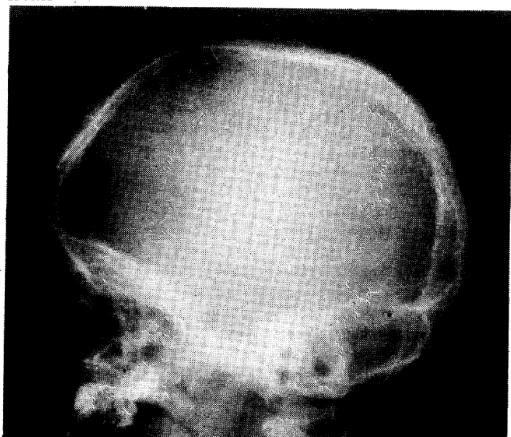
X-ray of skull showing thickening of calvarium and large size compared to facial skeleton. Sella is normal.
